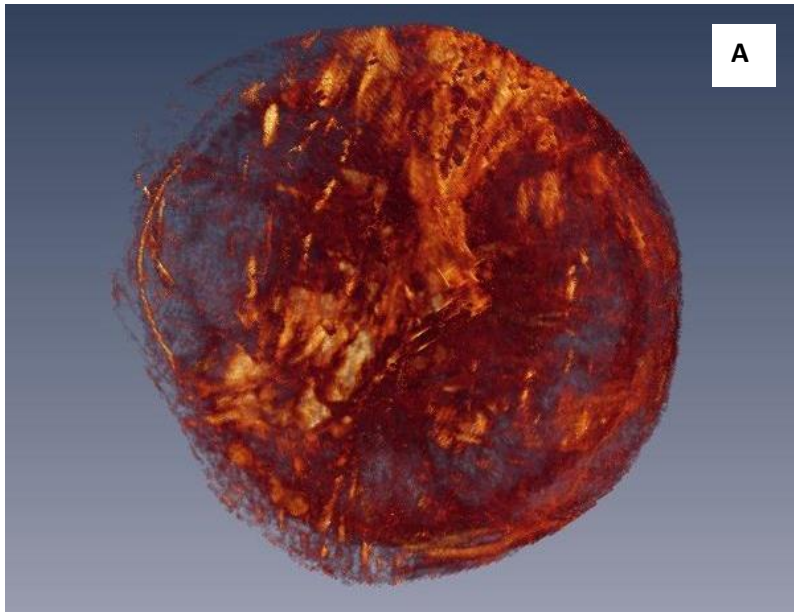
3D reconstruction from 2D MRI images of the placenta showing A) Maternal surface view, B) foetal surface view C) sideview. 3D volume rendering was performed using the visualisation software (Amira™).
